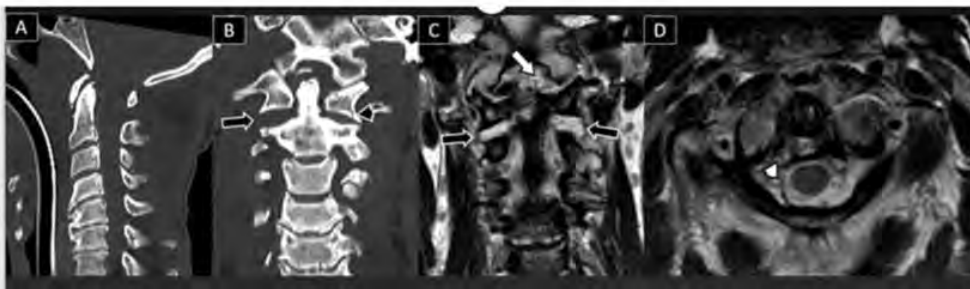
59-year-old male presenting to the ED after motor vehicle accident. Both radiologists identify the widening of the C1-C2 joint space on the right side (black arrow) with nondisplaced fracture of lateral mass of C1 on the left side (black arrowhead), consistent with a C1:C injury, C1:A injury. MR of the craniocervical junction (C, D) done later the same day corroborated the C1:C injury (black arrows), which now looks more prominent on the left side compared to the CT. However, complete rupture of the left alar ligament (white arrow, C0:B) and the right attachment of transverse atlantal ligament (white arrowhead C1:B) identified in MRI cannot be detected by both radiologists in CT image only.
